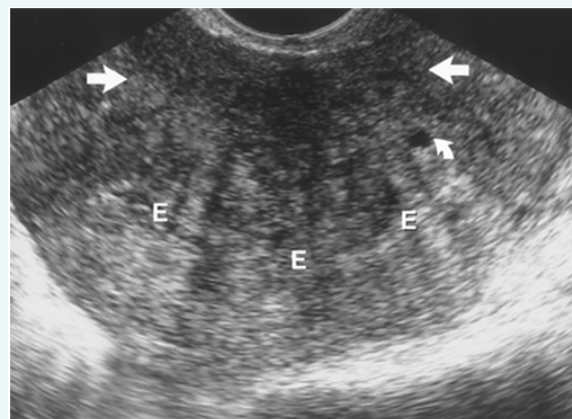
ultrasound findings of adenomyosis include decreased echogenicity of the anterior wall (large arrows), poor definition of the endomyometrial junction (E), and small myometrial cysts (curved arrow). From RadioGraphics, 19, S147-S160.
